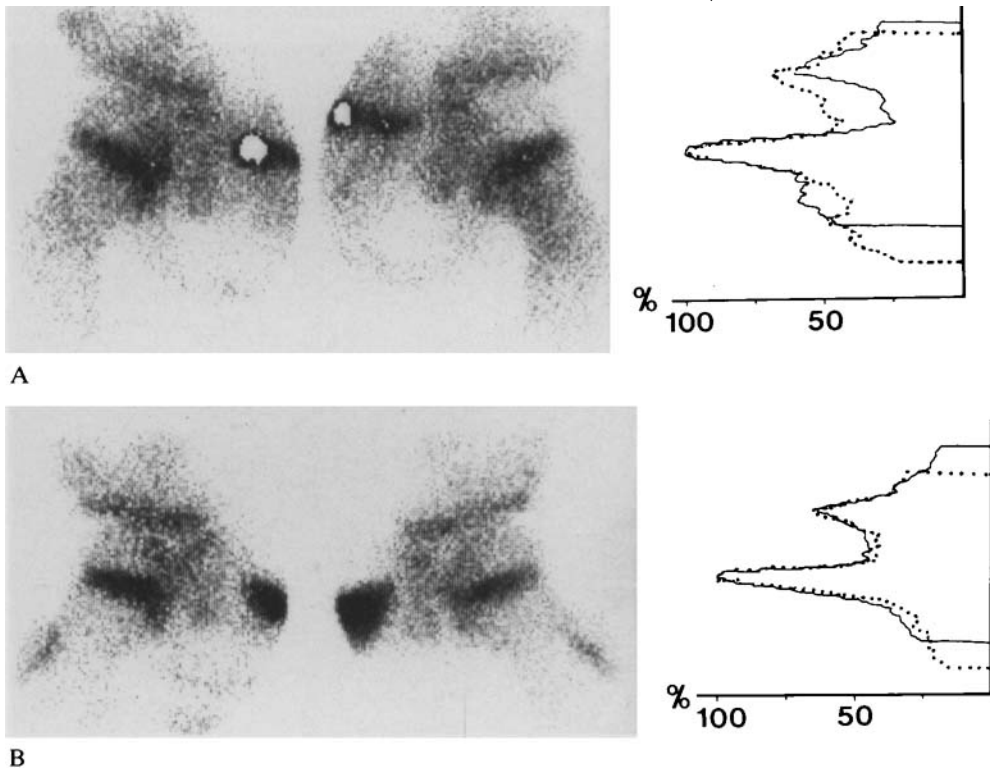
Case 2 with a transient ischaemia of the epiphysis of the left hip. This patient did not develop radiographic evidence of Perthes disease. Profiles of uptake superimposed as in Figure 16.
